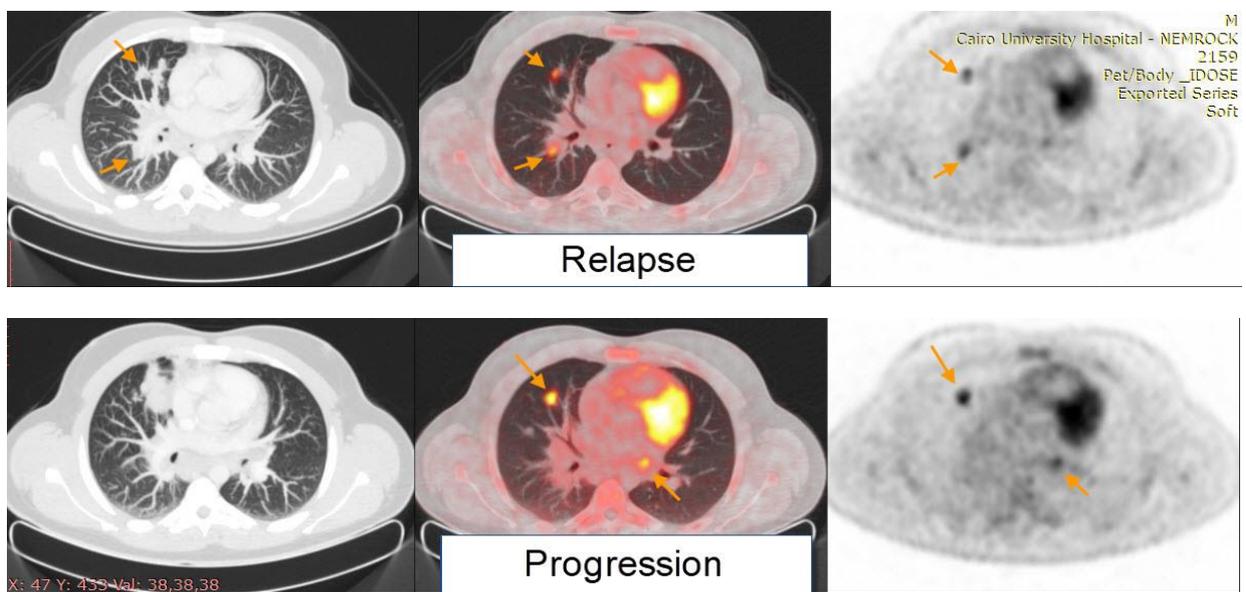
(B): The same patient with disease progression as PET/CT show increased FDG uptake involving right sided pulmonary lesions within the medial segment of the middle lobe and another lesion at the right hilar region. Lower row images show progressive increase in size and FDG uptake, however with imperceptible in right hilar LN.
